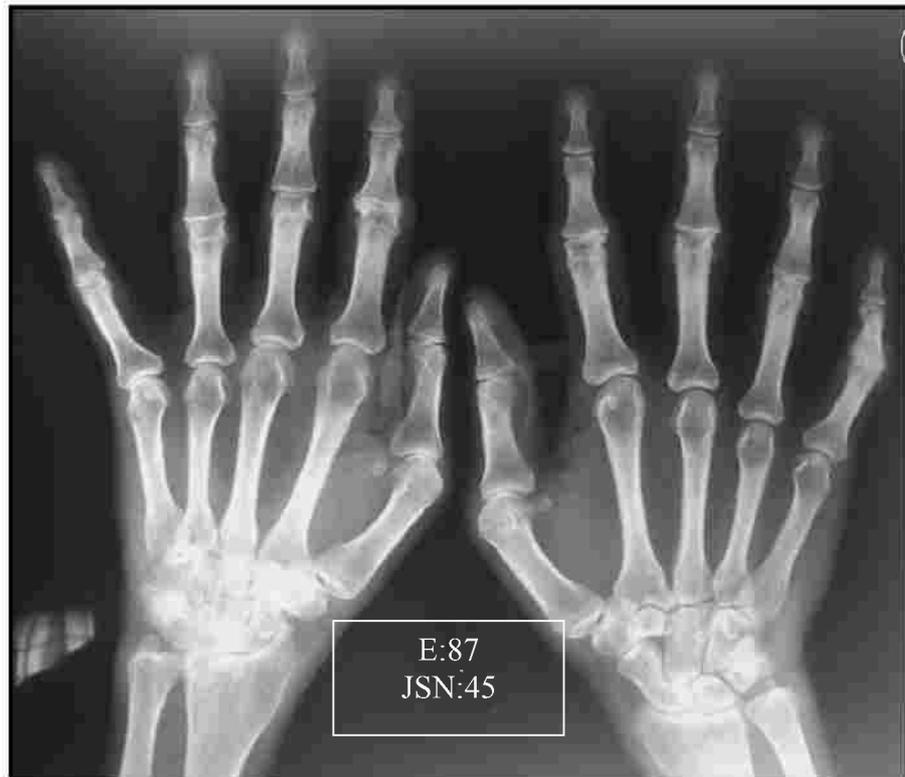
Plain X-ray of both hands and feet of a 32 years old ACPA positive RA patient with mTSS: 171. (E:erosions, JSN: joint space narrowing)
